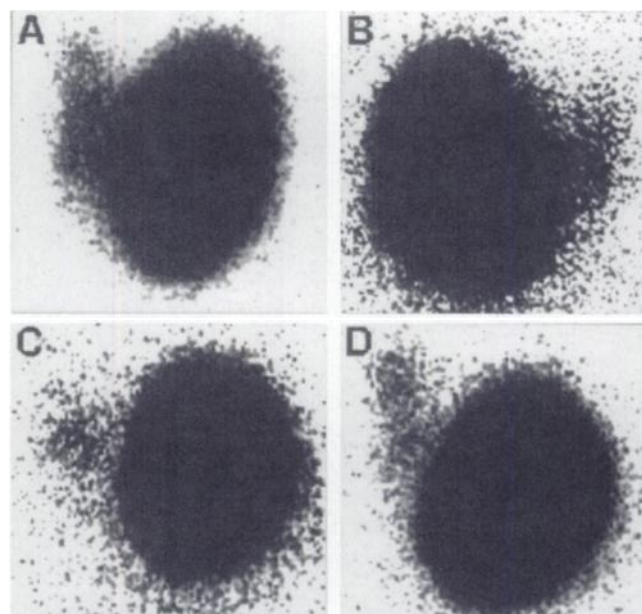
Examples of overexposed ^{123}I scintigraphic images at 24 h show “burned” nodule and varying degrees of contralateral lobe visualization in patients 2 (A), 6 (B), 8 (C) and 10 (D). At normal exposure only nodule was visible.
